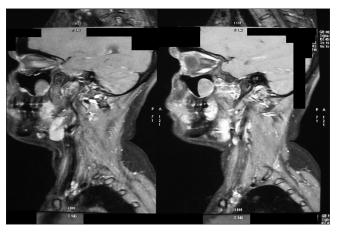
Magnetic resonance imaging scan showing lesion over the right premaxillary region
